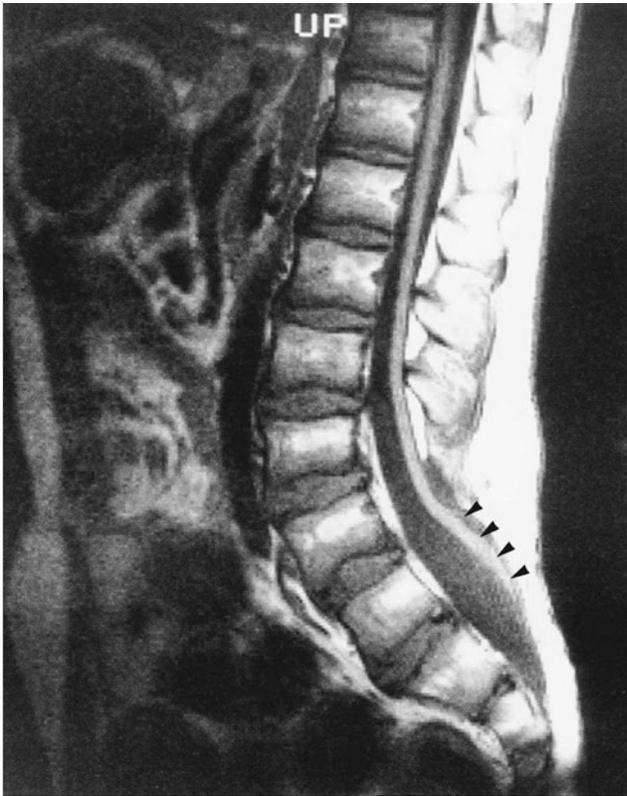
Tethered spinal cord. Midsagittal T1-weighted magnetic resonance image showing the spinal cord ending dorsally at the level of the L4–S1 vertebral bodies (arrowheads).
